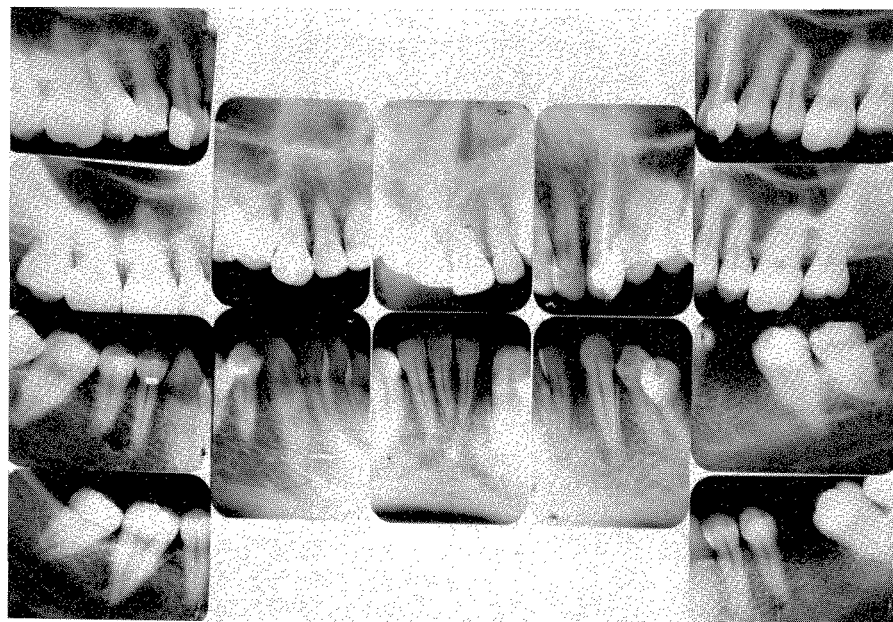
Roentgenograms taken in 1931 at the age of 31.
